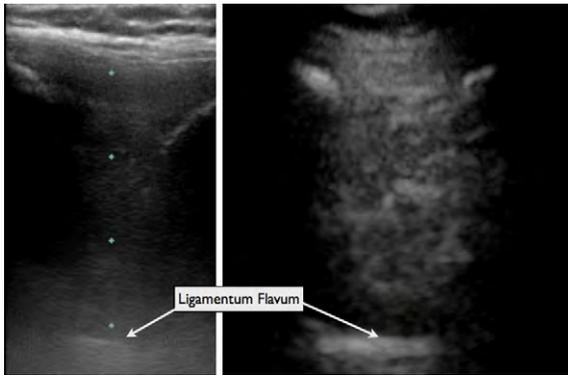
Ultrasound appearance of the ligamentum flavum. The left image is with use of a high-frequency probe, and the right image is with use of a low-frequency probe.
